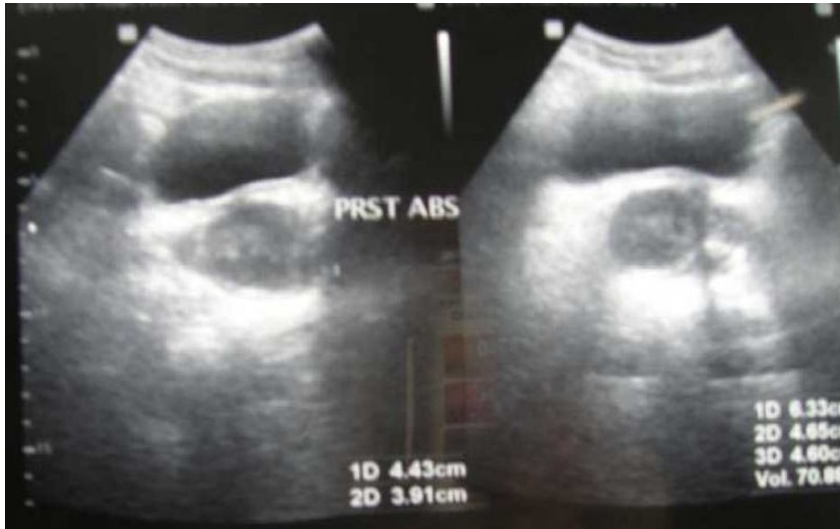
Show sonographic appearance of prostate abscesses..(Viable ultra sonnd CD.ROM)
